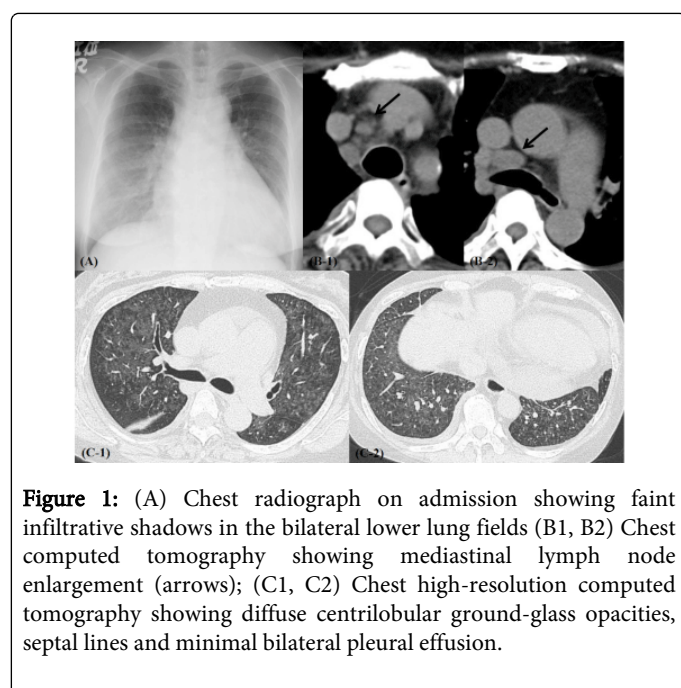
(A) Chest radiograph on admission showing faint infiltrative shadows in the bilateral lower lung fields (B1, B2) Chest computed tomography showing mediastinal lymph node enlargement (arrows); (C1, C2) Chest high-resolution computed tomography showing diffuse centrilobular ground-glass opacities, septal lines and minimal bilateral pleural effusion.
